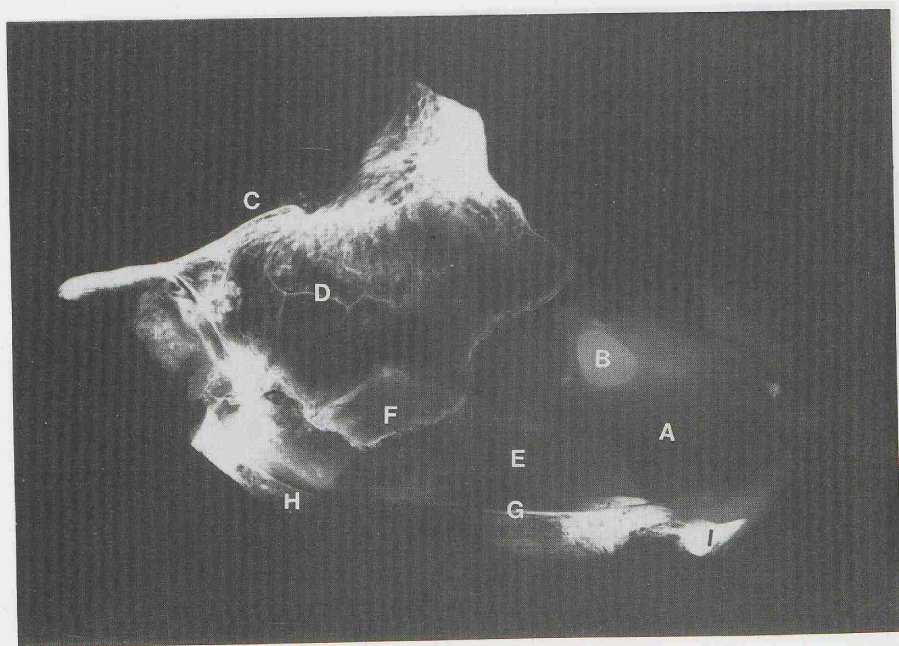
Lateral X-ray picture of nasal septum, age 17 years.
